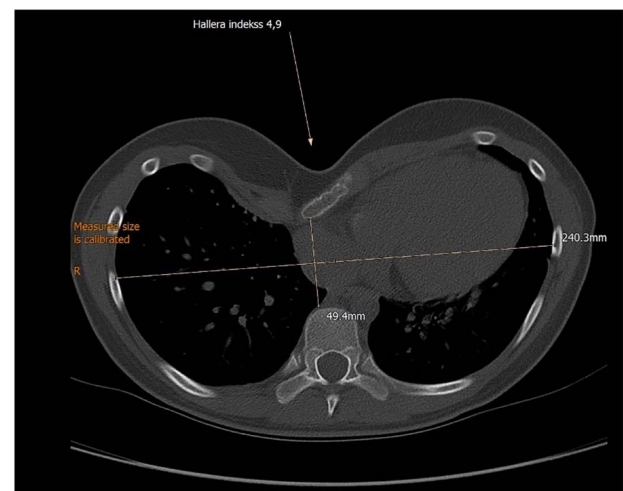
Preoperative computed tomography demonstrating severe pectus excavatum with Haller's index 4.9.
